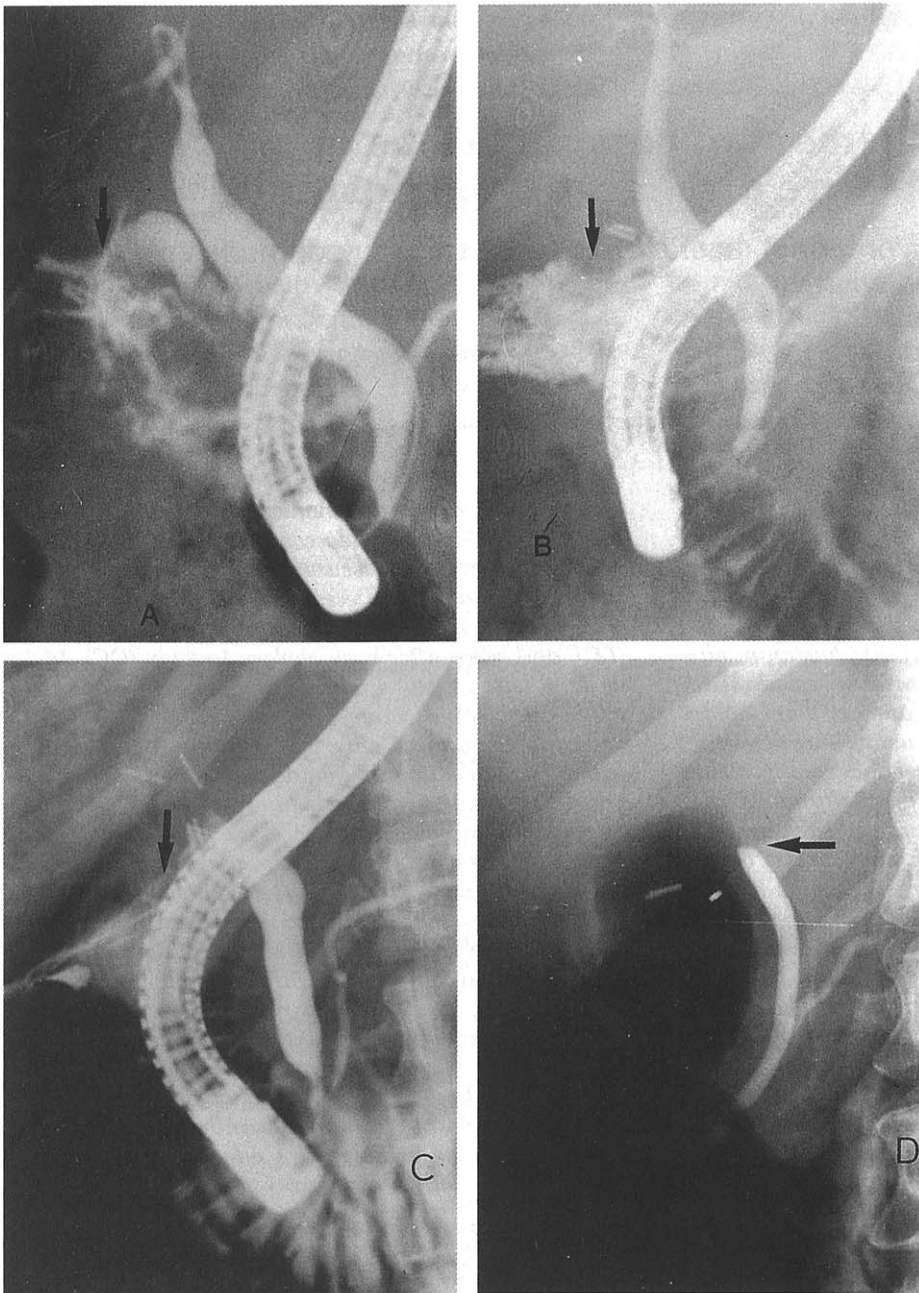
Radiograph shows cystic duct leak after LC. B. Retrograde cholangiogram showing moderate choledochal injury. Pooling of contrast below the level of clips. C. Severe injury of CBD; Oozing of contrast below the level of clips. Proximal part of CBD can not be visualized. D. Complete obstruction of CBD. This patient required pre-cutting. While ES was curative for the first two, last two patients required reconstruction.
